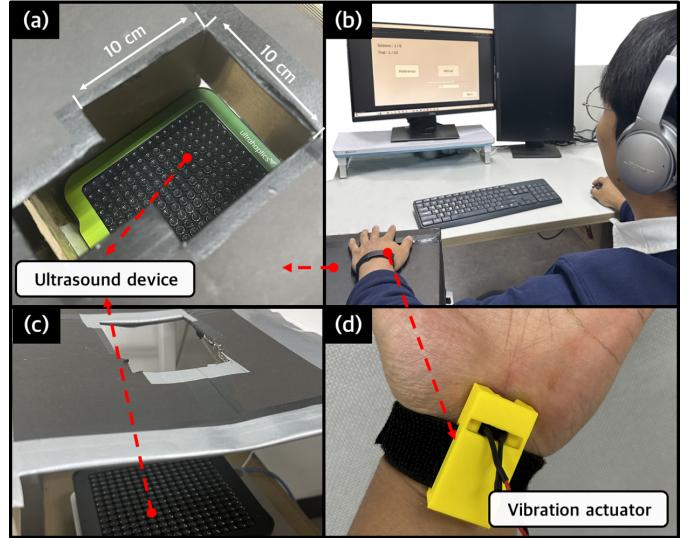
Experimental setup. (a) A mid-air ultrasonic haptic interface enclosed in a box for user study 1. (b) A participant wearing the wrist band, while conducting the experiment. (c) A mid-air ultrasonic haptic interface for user study 2, without the box walls to preclude any interference caused by the walls. (d) Vibration actuator attached to the wrist. Both mid-air and contact vibrations are applied to the same hand: palm and palmar wrist, respectively.
